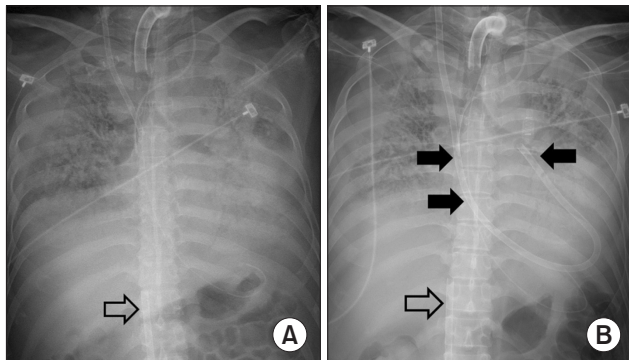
Chest radiographs before (A) and after (B) oxygenated right ventricular assist device (OxyRVAD) insertion. Filled black arrows mark the pulmonary artery cannula, whereas empty arrows indicate the tip of the draining cannula.
